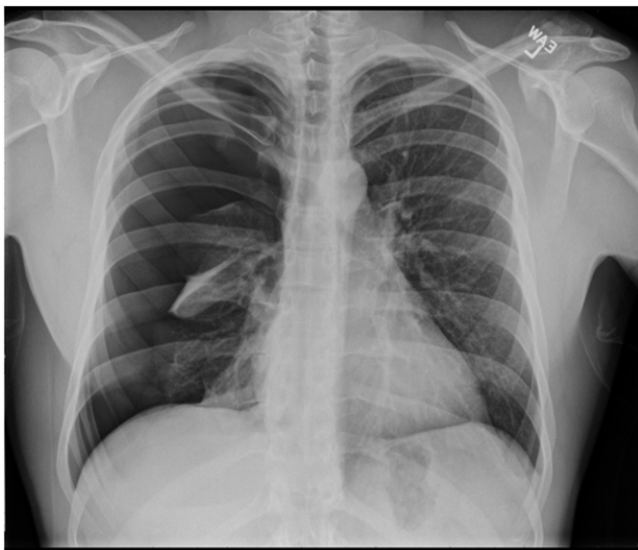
PA chest X-ray from at the patient's initial presentation. The right hemithorax is hyperlucent with collapse of the right lung consistent with a large right pneumothorax without radiographic signs of mediastinal shift. At the time the chest X-ray was taken, there were no clinical signs of tension PTX.
